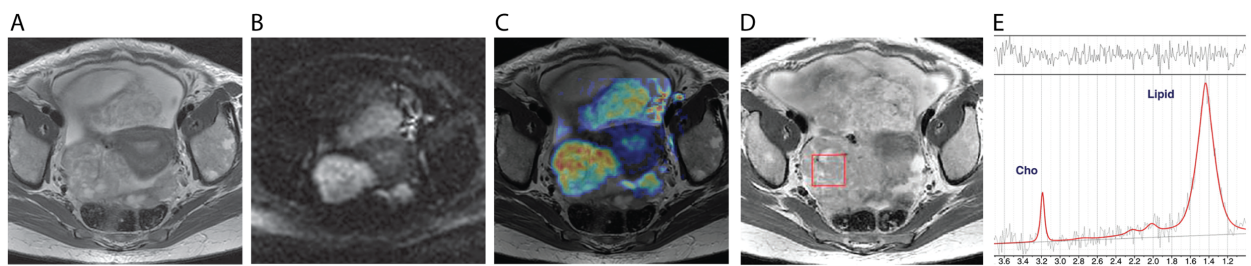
Multiparametric MR images (3.0 T) of a 58-year-old woman with advanced ovarian cancer.
